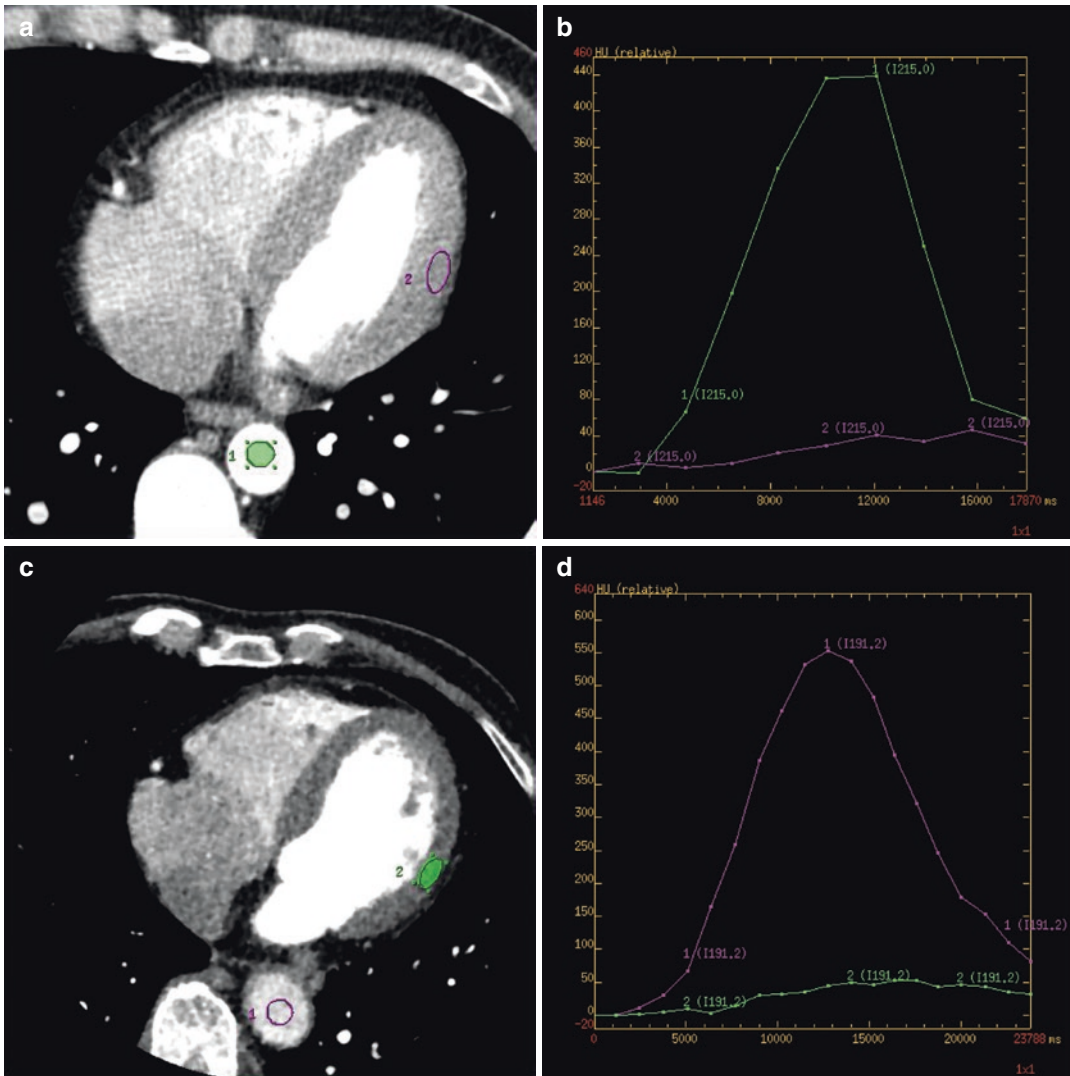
(a) Contrast-enhanced cardiac CT image and (b) the corresponding arterial and myocardial time-enhancement curves acquired with a CT scanner with limited axial coverage (4 cm). The CTP study was performed with an axial shuttling technique where the sampling frequency in each slice is about 2 s. (c) Contrast-enhanced
